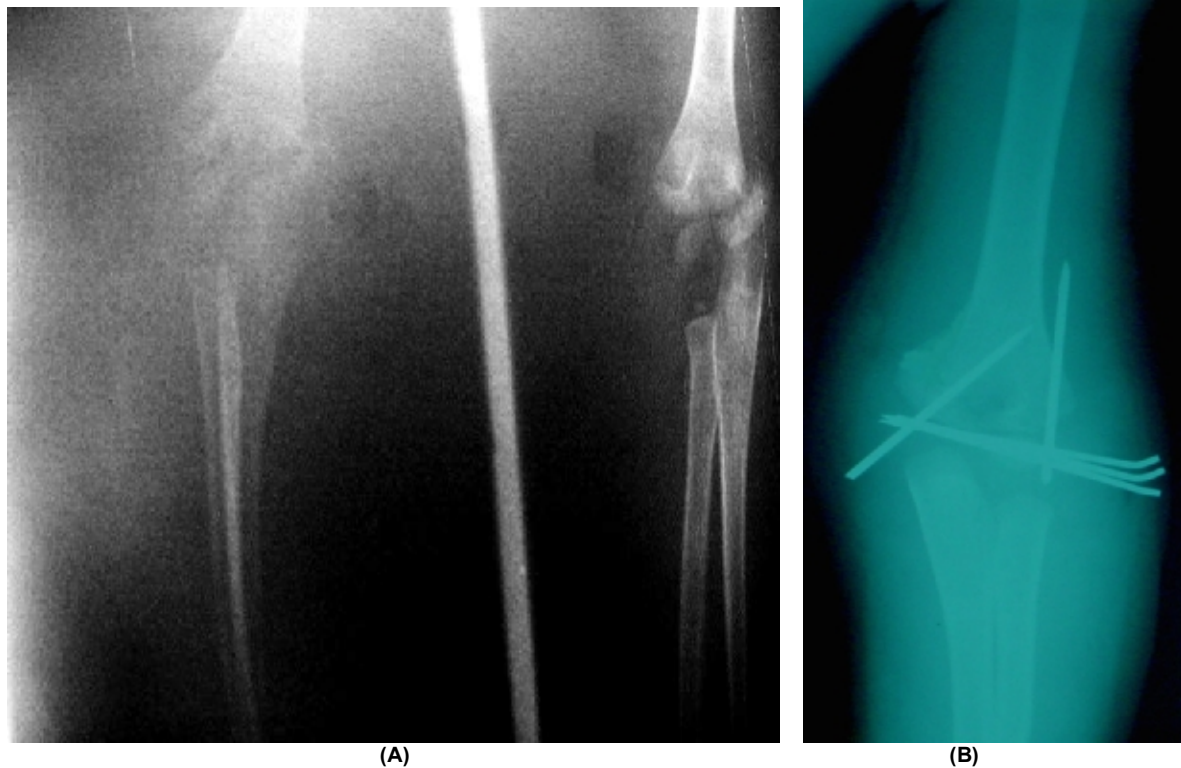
(A) a 5-years-old boy with intercondylar (T-condylar) fracture of the distal humerus. (B) x-ray control after open reduction and internal fixation.
